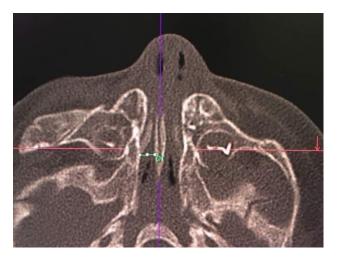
Computed tomogram of paranasal sinus axial section showing narrowed choanal air space, with a right choanal air space of 0.42 cm (D1).
